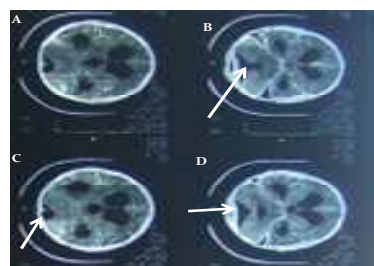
CT Scan report of the patient
